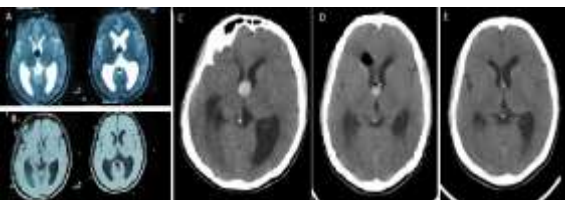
MRI images of colloid cyst showing hypointense cyst content on T2 weighted images(A) and isointense on T1 weighted images (B). Pre-operative CT scan (C) showing hyperdense cyst with subsequent resolution of cyst content (D and E)
